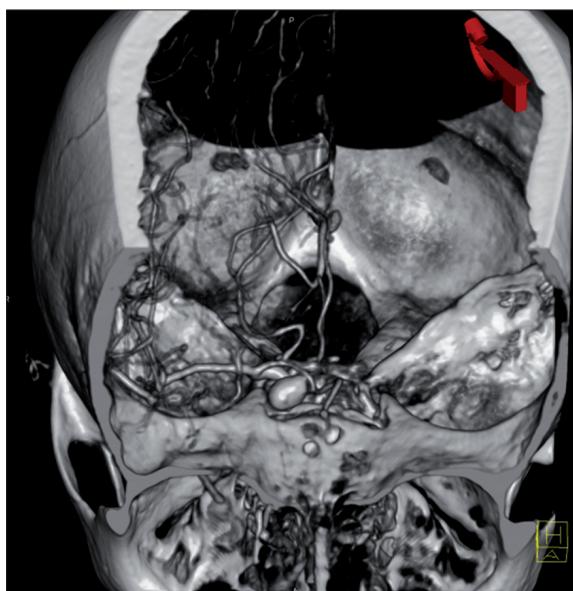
Dyna CT – VR reconstruction, internal carotid artery aneurysm.
